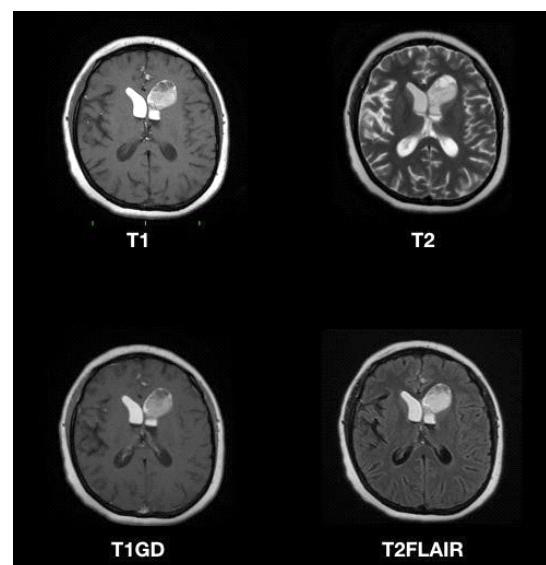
Magnetic resonance imaging with gadolinium taken in January 2020 of the present year, showing dermoid cyst in the different sequences.
